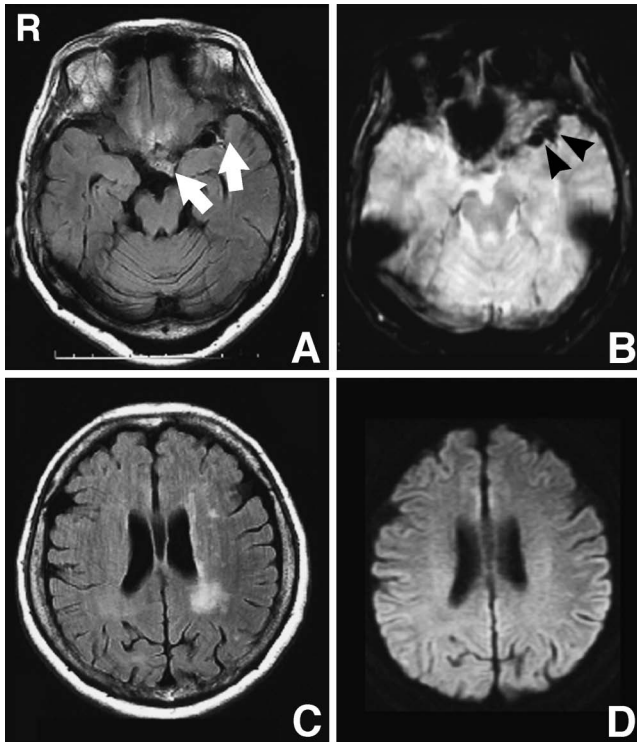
Preoperative magnetic resonance images showing an area of high intensity on the fluid-attenuated inversion recovery (FLAIR) image (A, arrows) and low intensity on the T₂*-weighted image (B, arrowheads) in the left sylvian fissure indicating recent subarachnoid hemorrhage, and an area of high intensity on the FLAIR image (C) in the left posterior watershed area without abnormal signal on the diffusion-weighted image (D) indicating past history of cerebral infarction.
